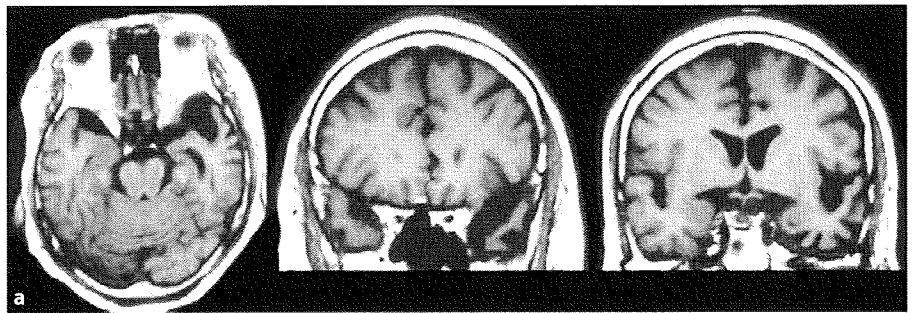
MRI findings of cases 1 and 2. a Case 1 (right-handed) at an early period in the clinical course. The parahippocampal gyrus, hippocampus and amygdala are preserved. b Case 2 (left-handed) at late period of the clinical course. Severe atrophy of the temporal lobe from the superior temporal to the parahippocampal gyrus as well as the hippocampus and amygdala, with right predominancy.
